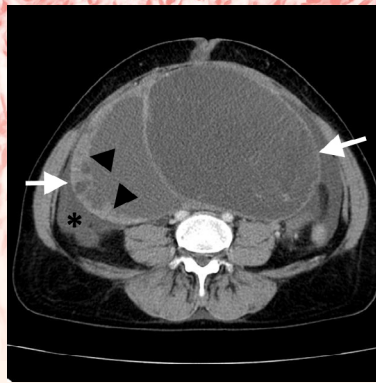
CT Scan showing a low grade serous carcinoma (LGSC) (white arrows) with thick cyst walls (arrowheads) and ascites (*).
